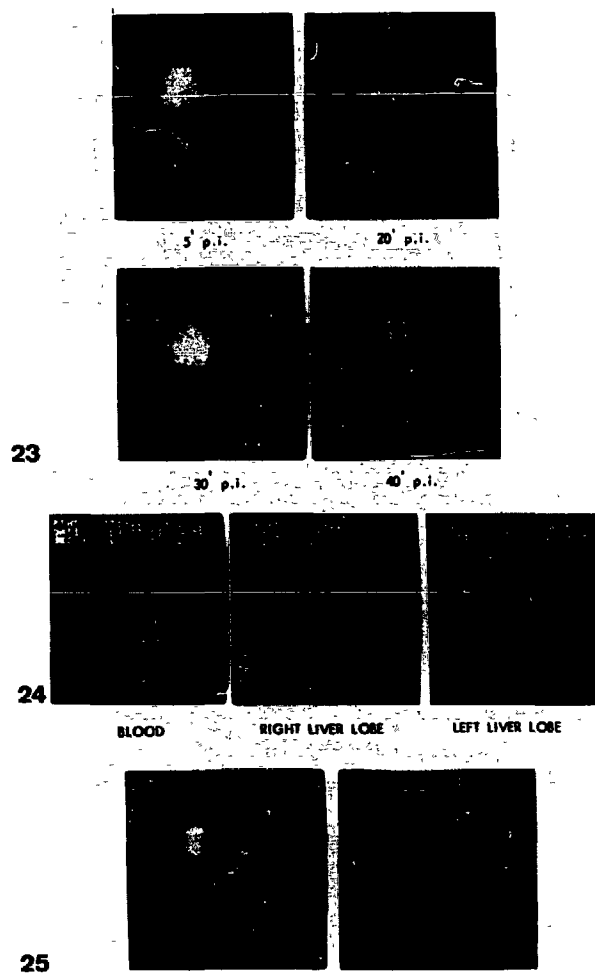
23-25 Cholescintigraphy in a patient with cirrhosis in the left liver lobe.
